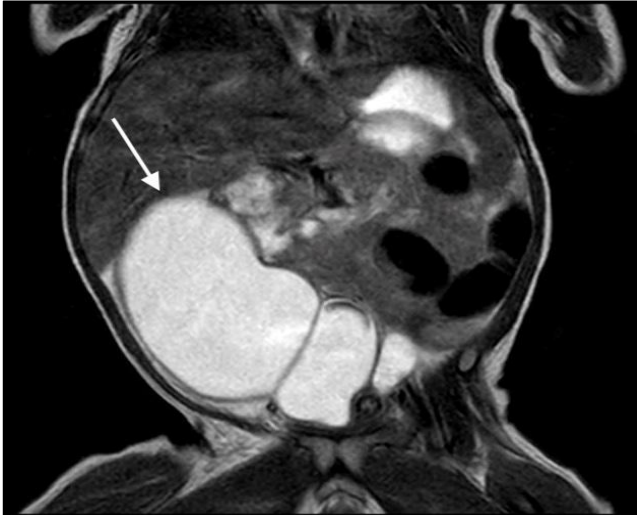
Coronal view of the pre-operative MRI showing a fluid filled mass with regular wall extending from the right hypochondrium to the pelvic floor (white arrow).
